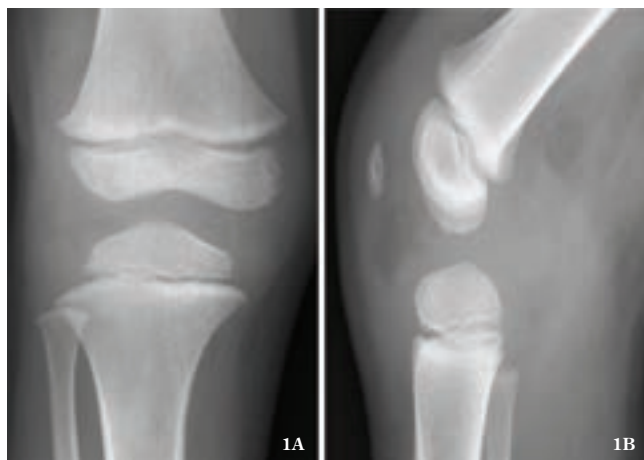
to 1B. The initial anteroposterior (1A) and lateral (1B) radiographs showed no osseous lesion.
